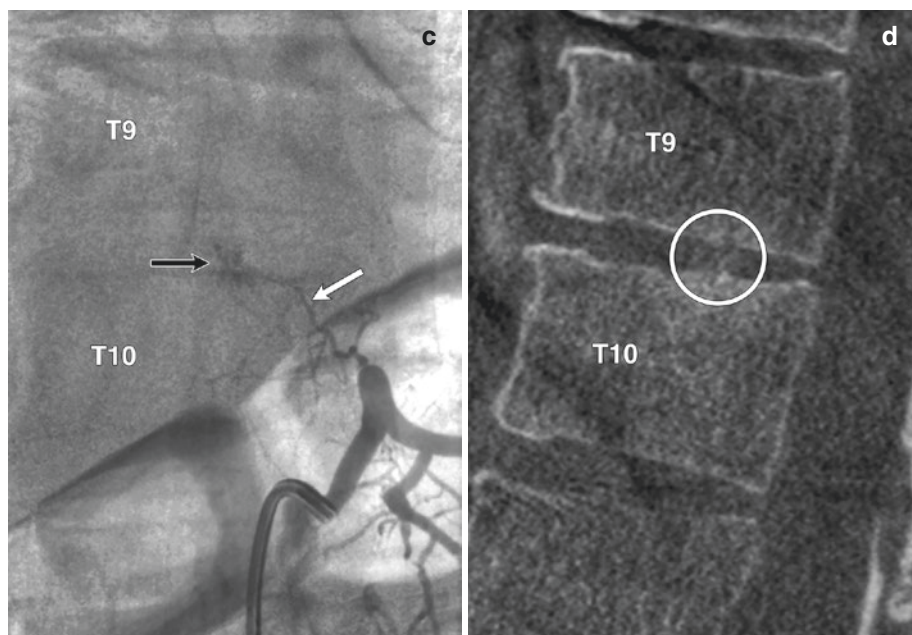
Angiographic appearance of a prevertebral adenopathy. (a) CTA, axial image at T11, showing a prevertebral adenopathy (*asterisk*). (b) Digital subtraction angiography (DSA), right T12 injection, posteroanterior projection; the blush associated with the adenopathy, supplied by an ascending anterolateral osseous branch
